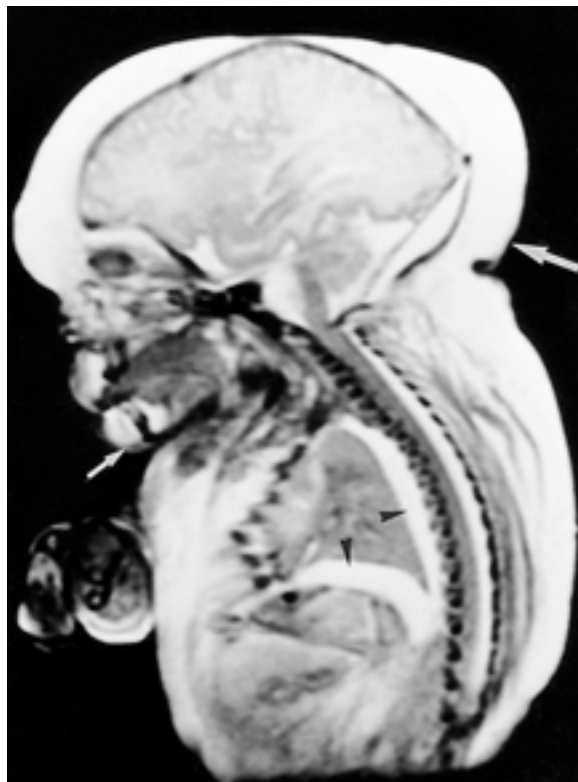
MR image of a 18-trisomy fetus.
